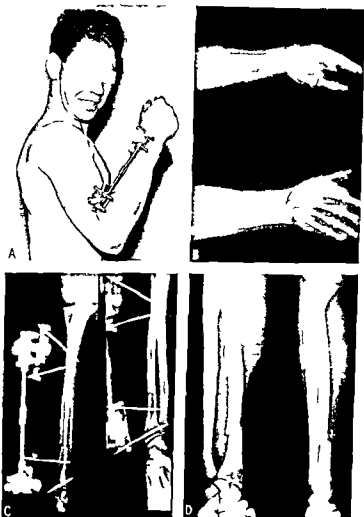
(Ca XV S N)—Transverse fracture of radial head, treated with distal fragment of middle third with distal fragment of middle third of radius. A. Standard plaster cast. B. Postoperative radiograph. C. Postoperative radiograph with wing film. D. Postoperative radiograph with wing film.
